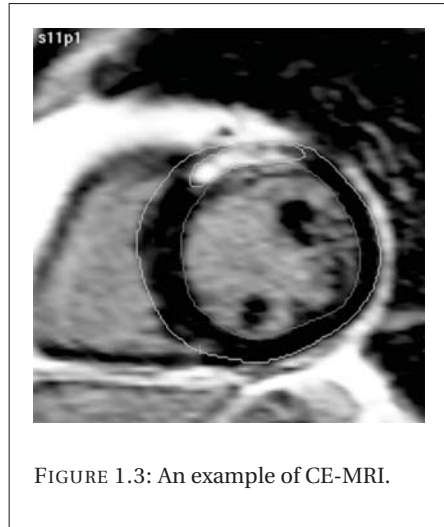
An example of CE-MRI.
